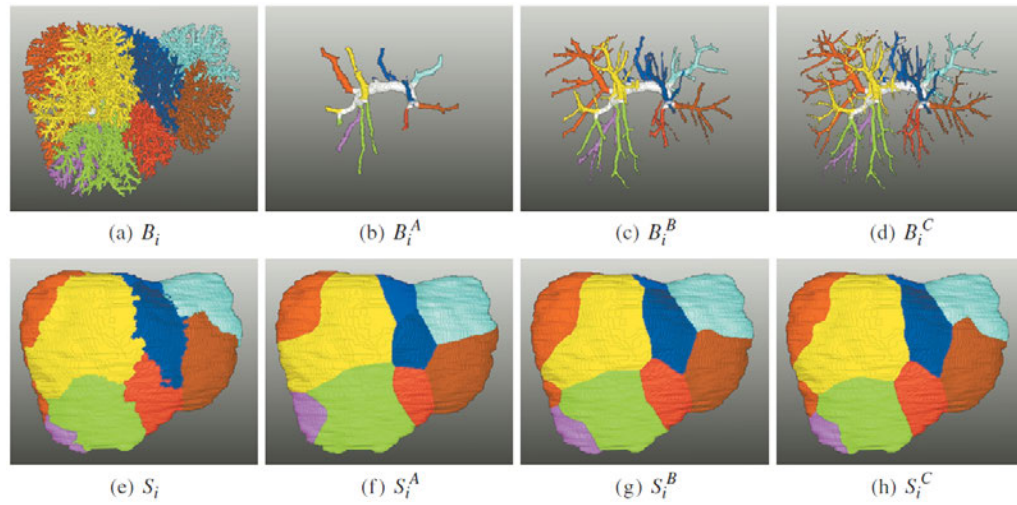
Evaluation of the nearest neighbor segment approximation approach using corrosion casts of the liver by Selle et al. [SSPP00]. The portal venous vessel system is extracted from a CT scan of a corrosion cast of the liver (a) and pruned with varying degrees (b-d). Corresponding Couinaud segmentations (f-h) are compared with the ground-truth segmentation (e). Image taken from [SSPP00].
